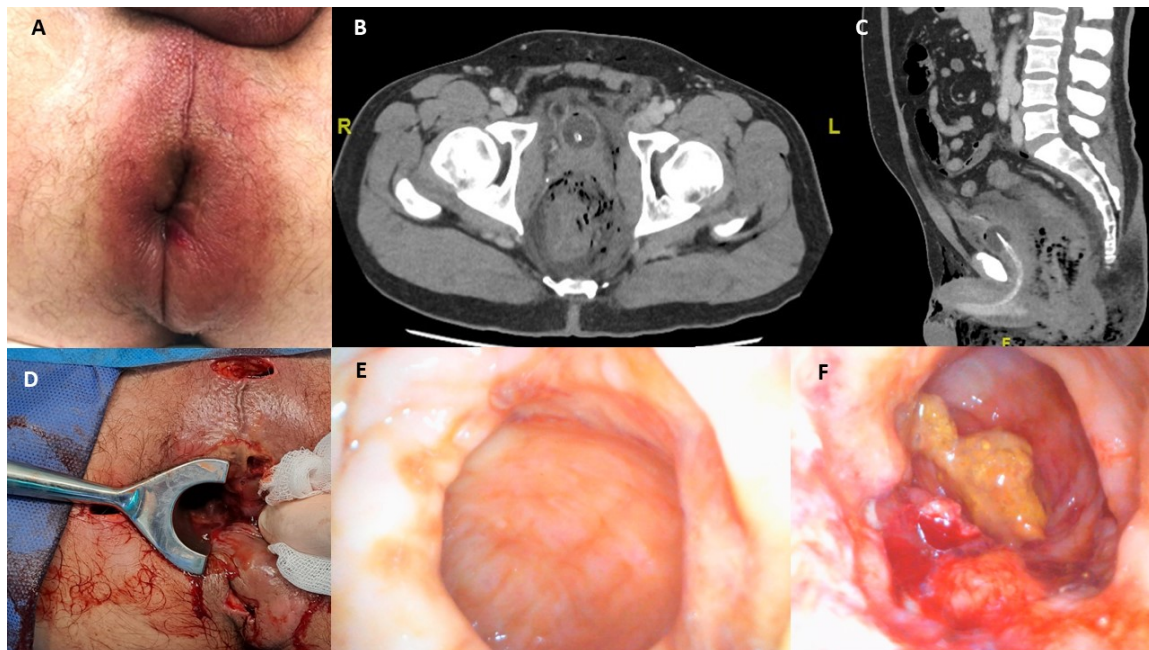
A) Severe perianal inflammation without fluctuation or suppuration. B) C) CT scan findings: free air in mesorectum and retroperitoneum without intraperitoneal free air or fluid. D) Long and deep anal and rectal fistulas were seen during the second examination under anaesthesia. E) F) Rectal ulcers on the rigid rectoscopy
